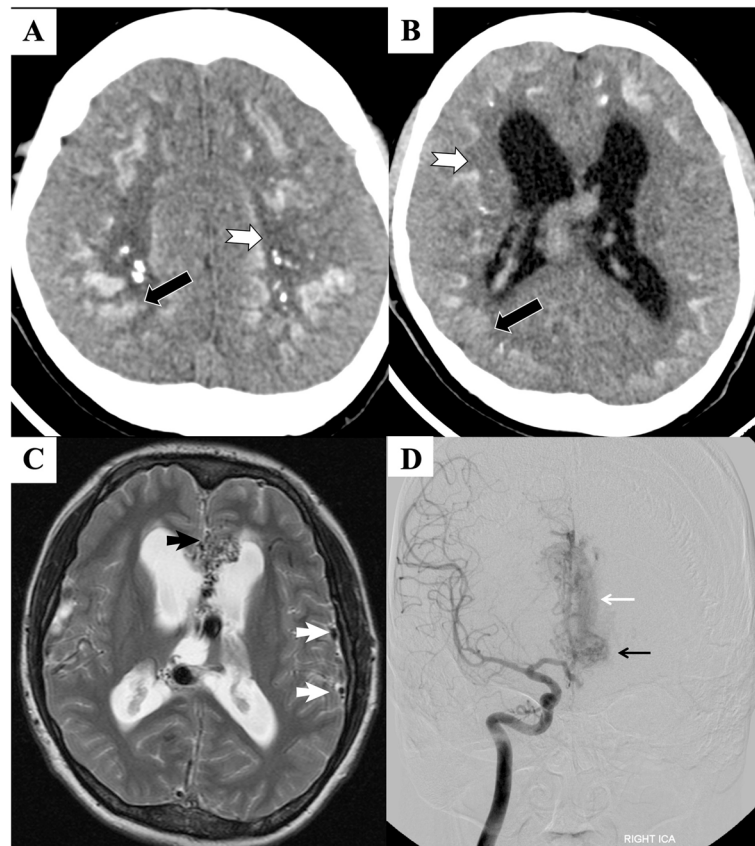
a, b Axial NCECT brain shows subcortical calcification (black arrow) and white matter hypodensity (white arrow). c Axial T2W MRI brain shows dilated veins (white arrowhead) and nidus of AVM (black arrowhead). d DSA of right ICA shows nidus of AVM (small black arrow) and large draining vein (small white arrow). Note dilated ventricles on NCECT (b) and MRI (c)
